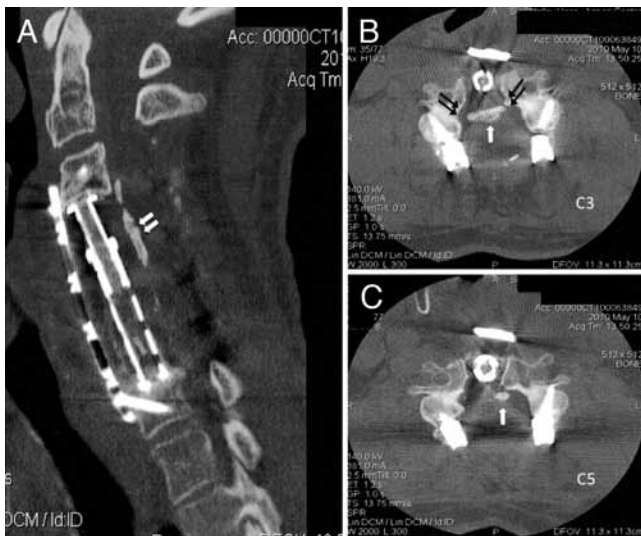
Postoperative CT scans demonstrating ventral decompression supplemented with anterior fusion with a plated cage and posterior laminectomy and fusion in the patient in Fig. 3. A central ossified bar was left in place following extensive lateral decompression. A: This “floating” bar can be seen on the sagittal midline CT (arrows). B and C: Axial image obtained at the C-3 level (B) demonstrating the extent of lateral decompression (black arrows) and remaining midline bar (white arrows in B and C). At C-5, a single pearl of ossified bone remains (C).
